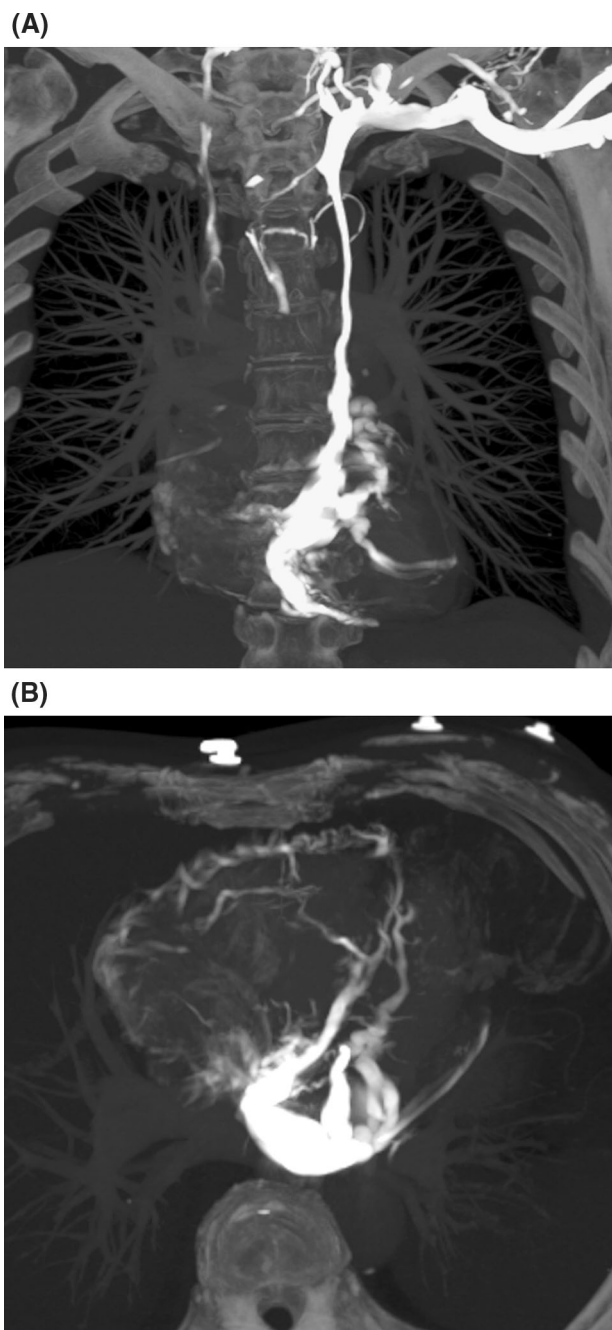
CT phlebography. A Thin-slab reconstruction using the maximum intensity projection algorithm in the coronal view showing occlusion of the IV and patent left superior vena cava connected to the coronary sinus, which is connected to right atrium. Notice the high-grade ostial stenosis of the coronary sinus. B Axial view reconstruction using the same algorithm shows dilatation of the coronary sinus and its affluents
